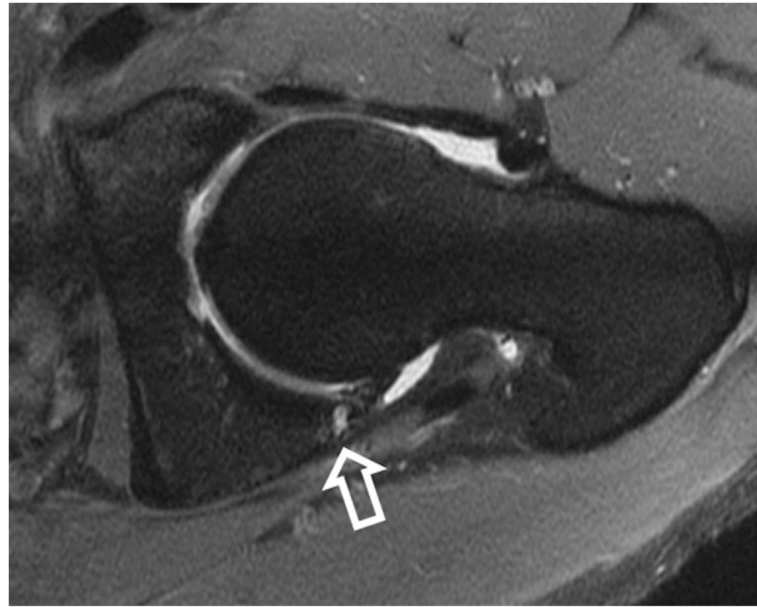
Sagittal fat-saturated T2-weighted MR arthrographic images of the left hip demonstrates complete chondrolabral separation of the anterosuperior labrum (arrow).
